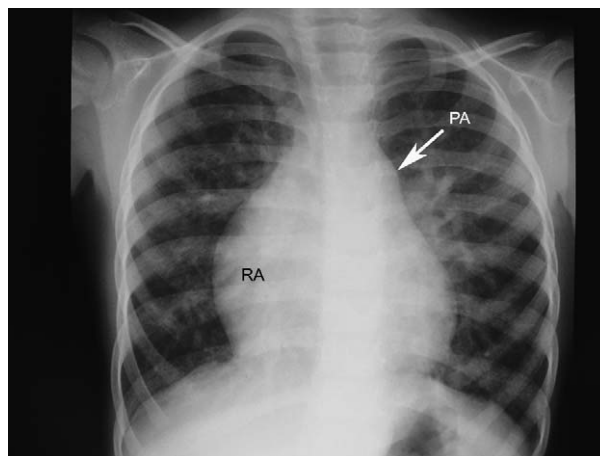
Chest X-ray (CXR) typical of atrial septal defect (ASD). Right atrial (RA) and right ventricular (RV) hypertrophy, with enlargement of the pulmonary artery (PA) and increased pulmonary vascular markings.
